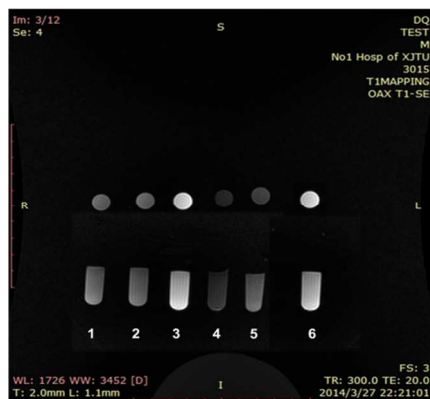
T<sub>1</sub>W<sub>i</sub> reference images (1: H<sub>2</sub>O; 2: Magnovist; 3: Gd<sup>3+</sup>@CGO; 4: GO; 5: CGO; 6: Gd<sup>3+</sup>@CGO after dialysis against deionised water for 1h with assistance of ultrasonic vibration).
